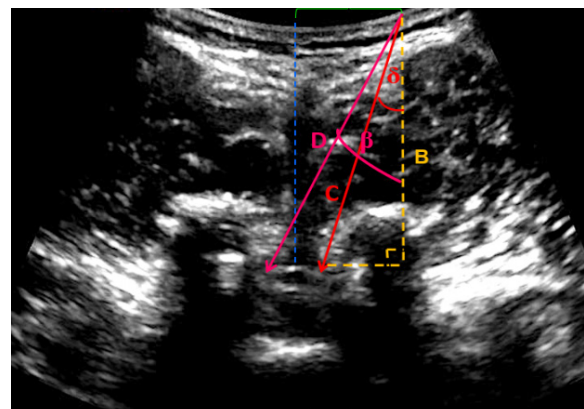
Transverse median view (TM view) of neuraxial ultrasound scanning.
